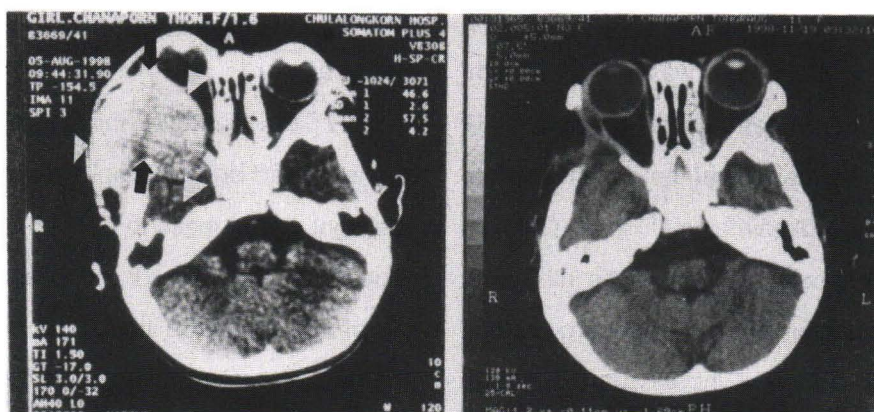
Preoperative CT scan of brain and orbit showing large, homogeneous, enhancing soft tissue mass involving right temporal region, retrobulbar space, orbital apex. and intracranial extension. (white arrow head) A large lytic bone lesion is shown.(arrow)
